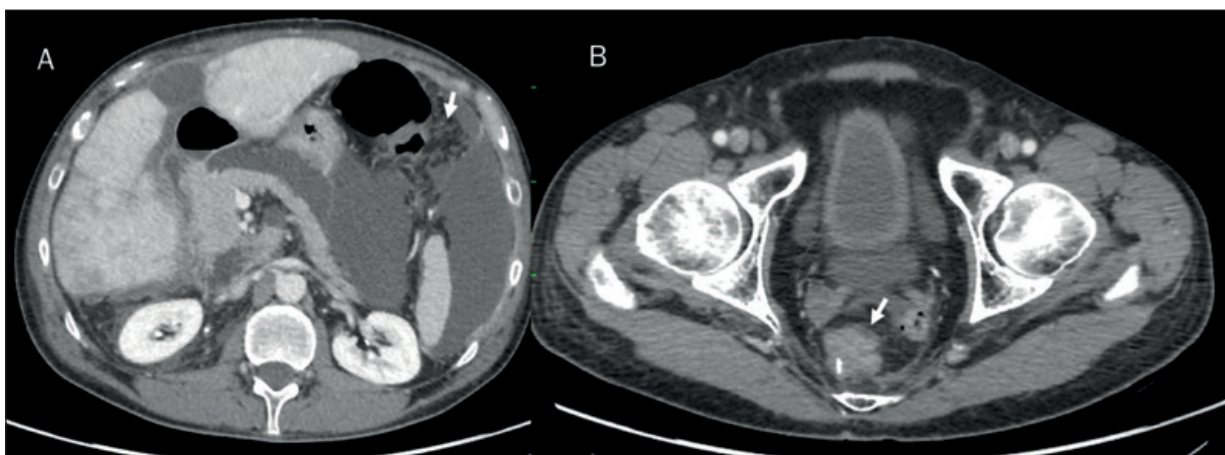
Patient subjected to mesorectal cancer excision with recurrence in peritoneal (in A, the arrow shows PC) and in pelvis side (in B, the arrow shows recurrence), assessed on contrast CT study.
